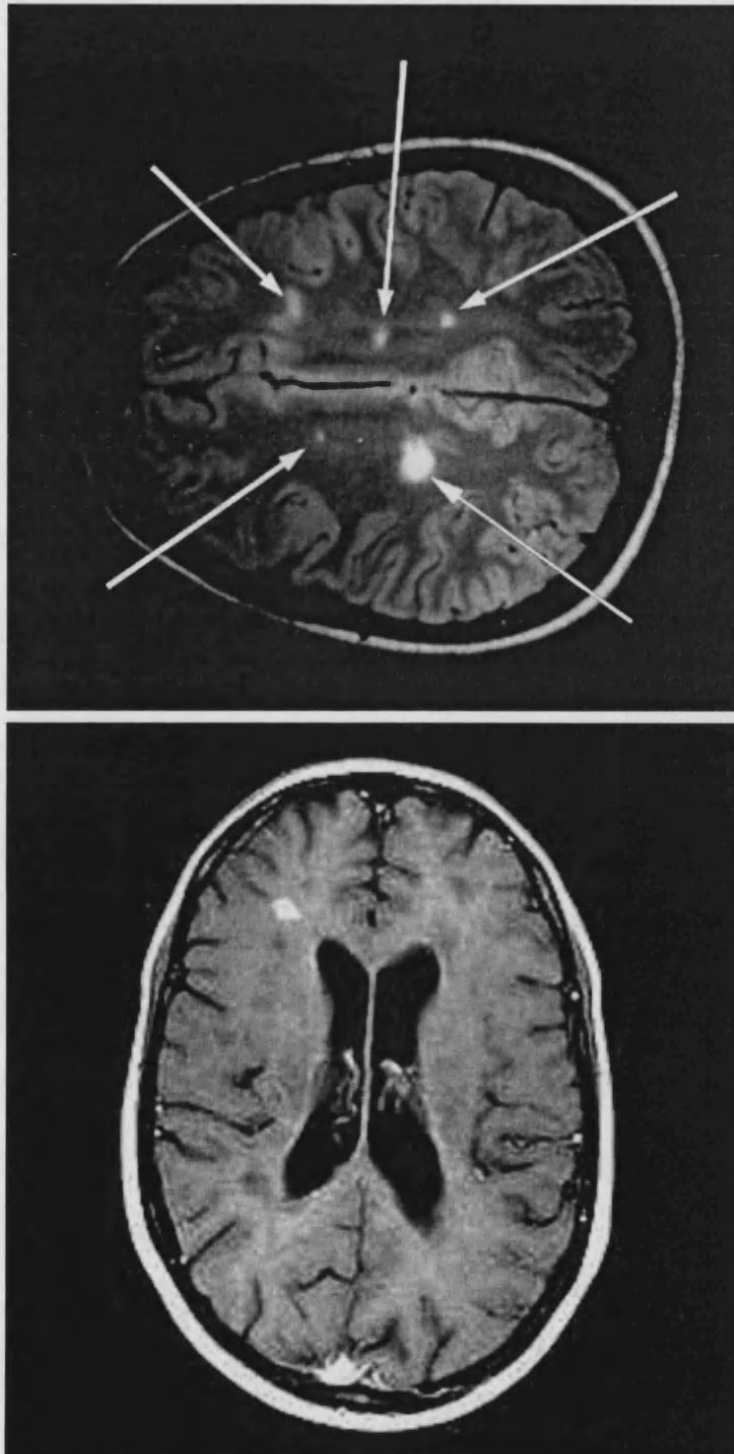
Lesions in the brain in multiple sclerosis, as visualised by magnetic resonance imaging, appear as light areas on a darker background. Location of a lesion in a brain structure dictates whether it is a "silent" lesion, or if it will elicit clinical symptoms. For instance, a lesion in the motor cortex can cause tremor or loss of movement function. From: Multiple Sclerosis (Edited by Paty D.W., Ebers G.C.; 1997; Philadelphia, Pa. F.A. Davis)
